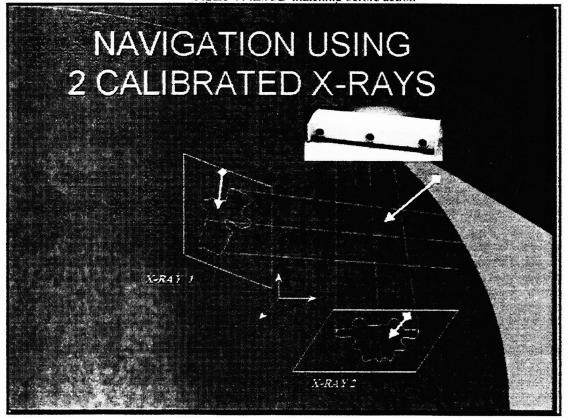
navigation using 2 calibrated X-rays
